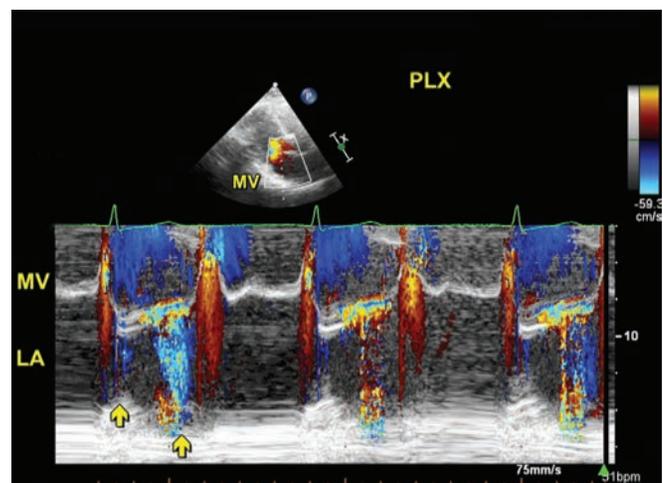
Color M-mode examination. Left arrow points to minimal MR resulting from closing movement of the MV. Right arrow shows mid to late systolic MR. (PLX: parasternal long axis view).
